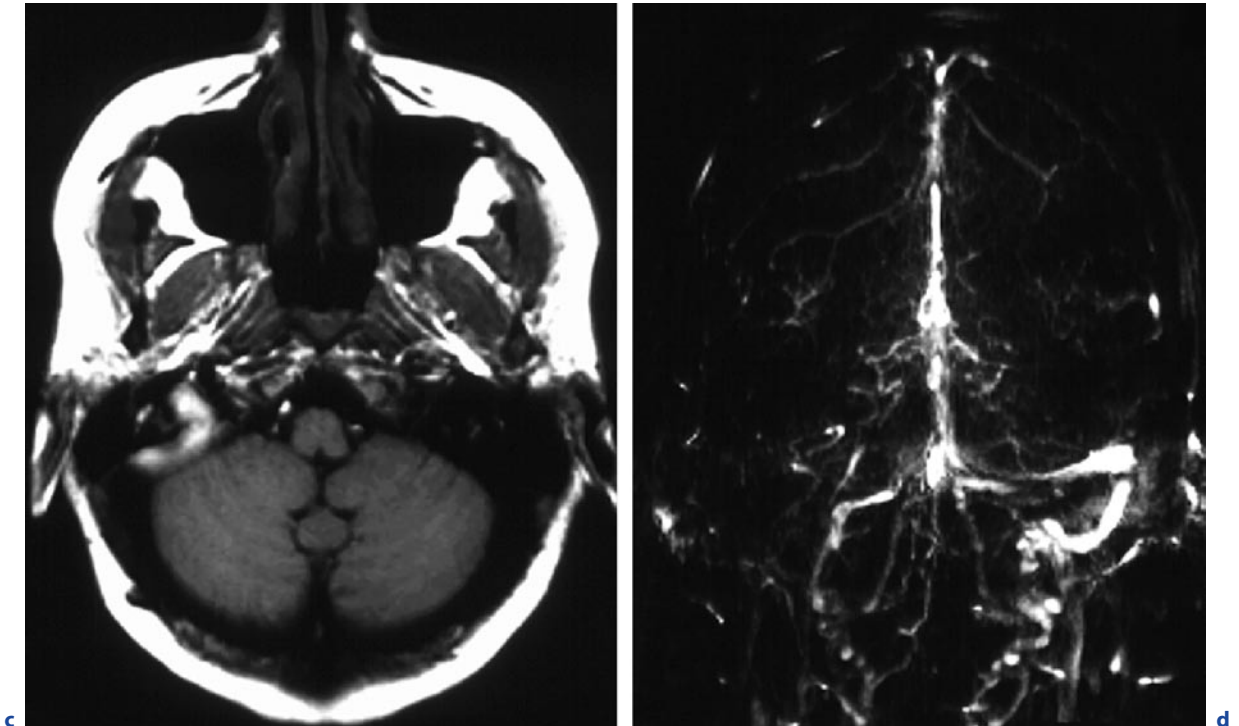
(continued) Vasogenic edema due to sinus thrombosis as differential diagnosis of cerebritis. A 36-year-old woman, headache, seizures for 10 days. c Axial T1-weighted images without contrast administration. d MIP of venous TOF
